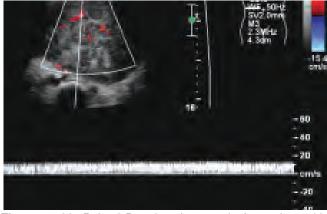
Pulsed Doppler ultrasound of a patient with degenerative fibroid. Note venous type of the blood flow signals obtained from the central portion of a degenerative fibroid
